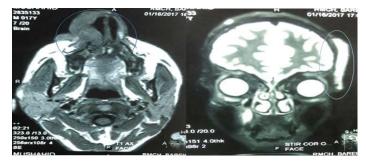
a Axial section of MRI showing Epithelial cystic mass at right Lateral part of nose. b: Coronal section of MRI showing mass at left temporal region.
